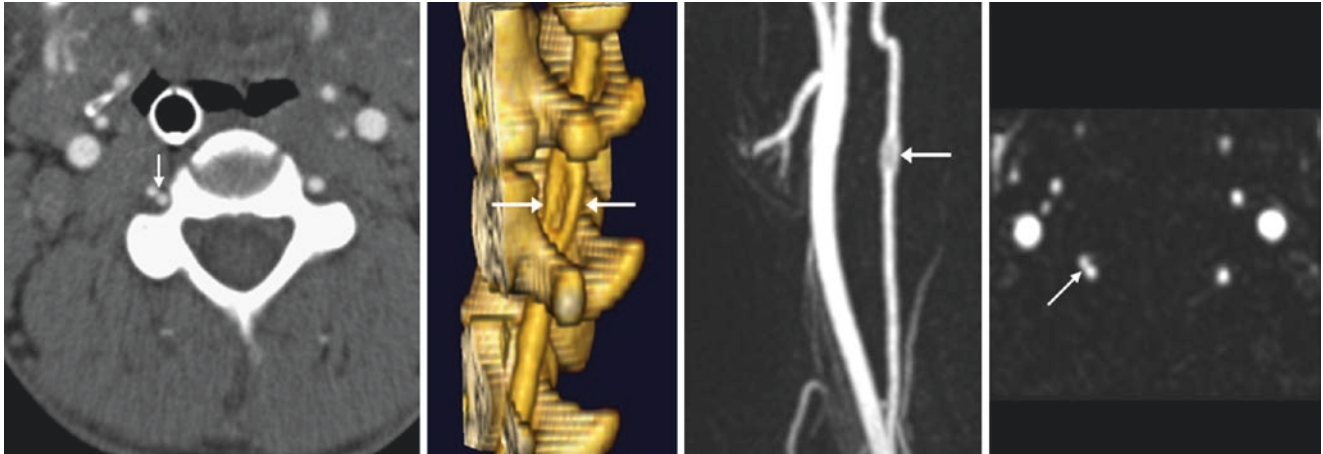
23-year-old with a cervical vertebral artery (VA) fenestration (*arrows*) on 0.8-mm source CTA images (*left*), 3D VR CTA lateral view (*left middle*), and on a contrast-enhanced MRA AP view (*right middle*) with axial source images (*far right*)
